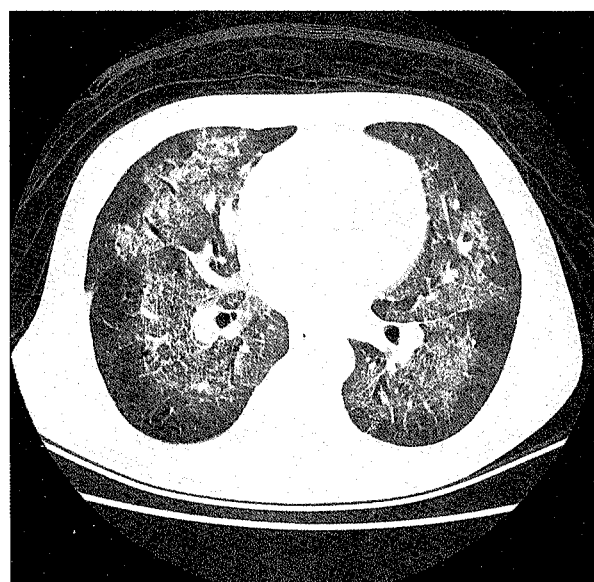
Chest CT: ground-glass pattern.
